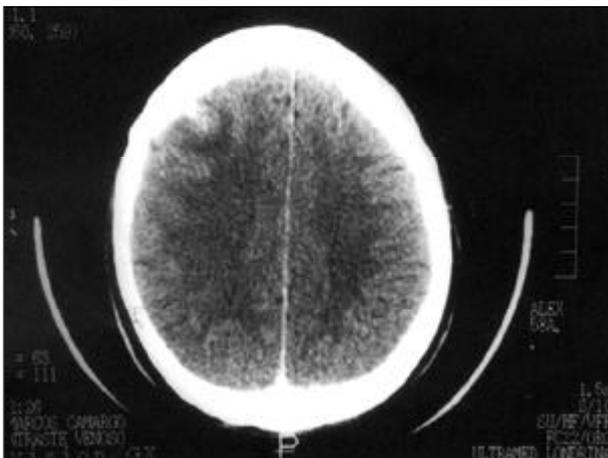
Embolism to the central nervous system. Computed tomography of the skull depicts a nodular ischemic area of 2.0 cm in the cortical region of the right frontal lobe.
